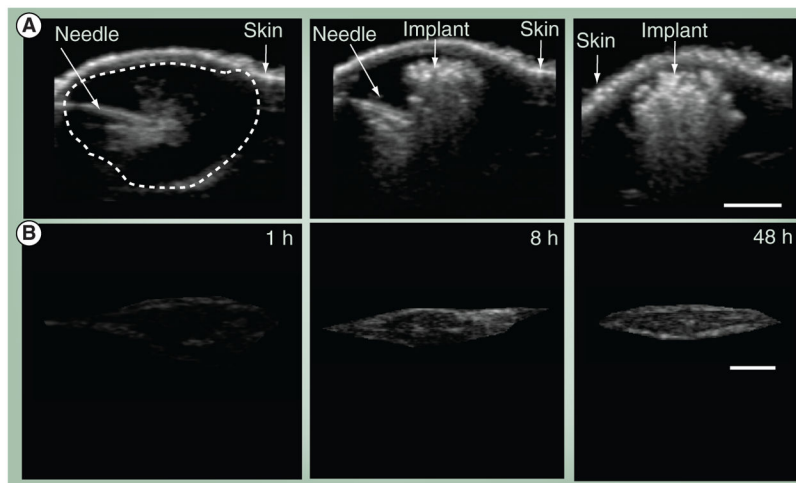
In vivo* ultrasound imaging for the evaluation of implant formation
